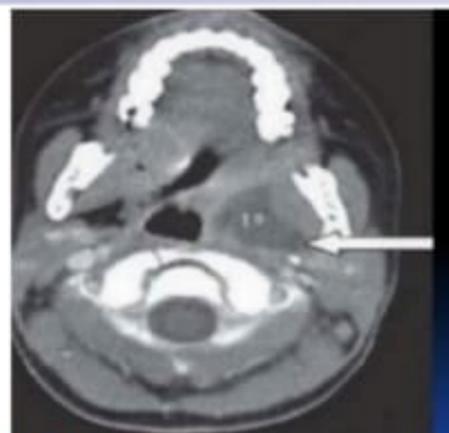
a: Parapharyngeal abscess –CT scan Head and Neck-axial view
